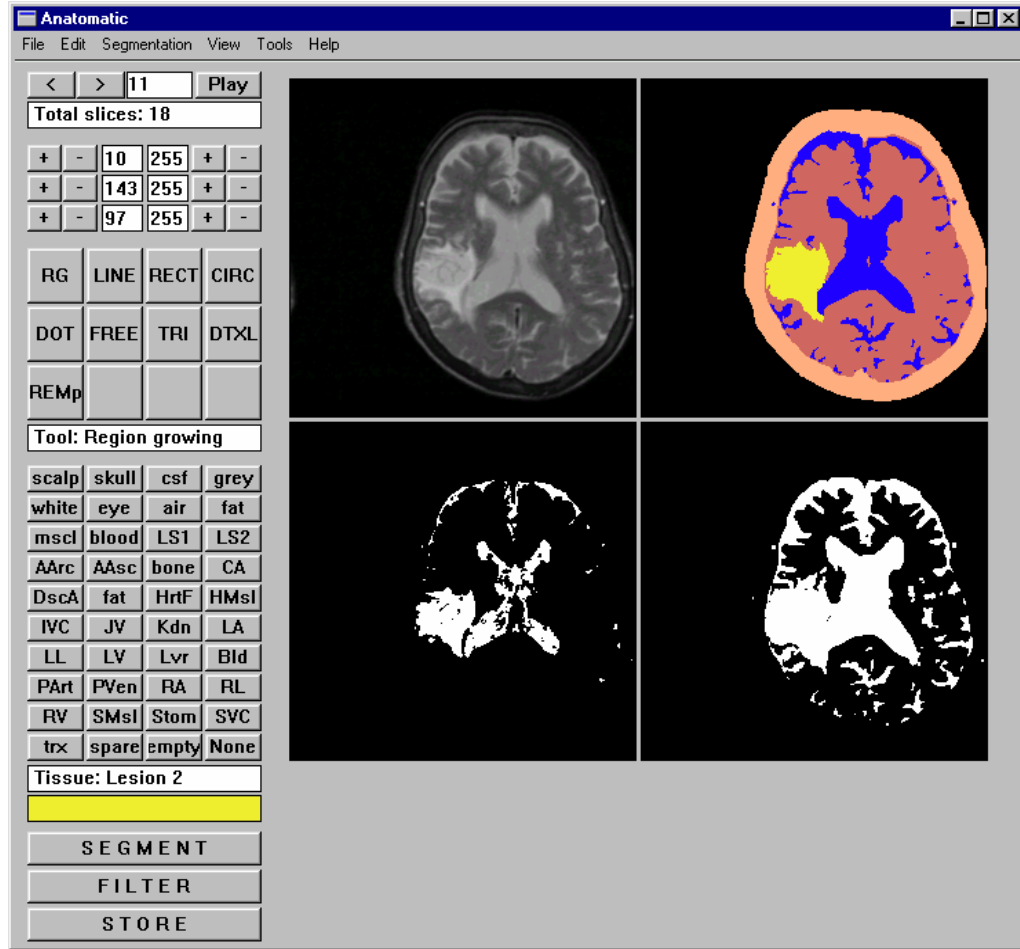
The user interface of AnatomaticTM software used in volumetric analysis of lesions in various diseases. The left upper figure represents the original MR image with an infarction seen as high signal intensity on a T2-weighted image. The right upper figure represents the segmented image of the infarct; also other structures of the brain like the cerebrospinal fluid, and the rest of the parenchyma have been segmented. The lower two figures represent the amplitude-segmented pictures, where using different threshold intensities the images have been modified to look similar to the original MR image in the left upper corner.
